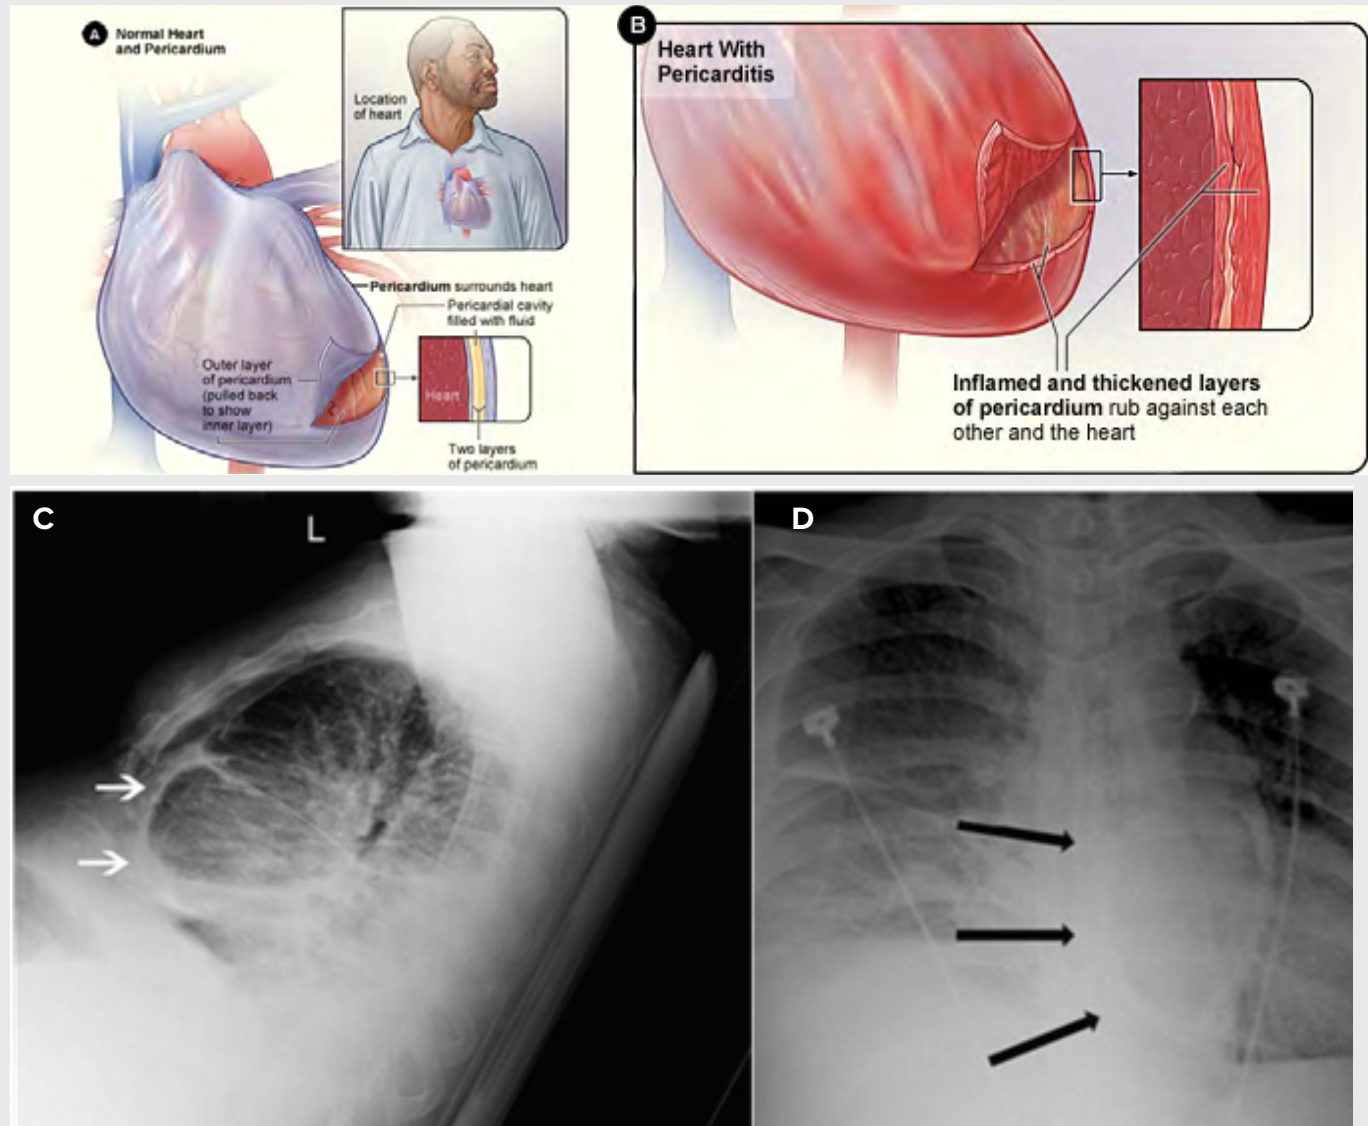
(A) Normal heart and pericardium (the sac surrounding the heart); The inset image is an enlarged cross-section of the pericardium that shows its 2 layers of tissue and the fluid between the layers. (B) The heart with pericarditis. The inset image is an enlarged cross-section that shows the inflamed and thickened layers of the pericardium. (C) and (D) Lateral and postero-anterior Chest X-rays showing pericardial calcifications.
